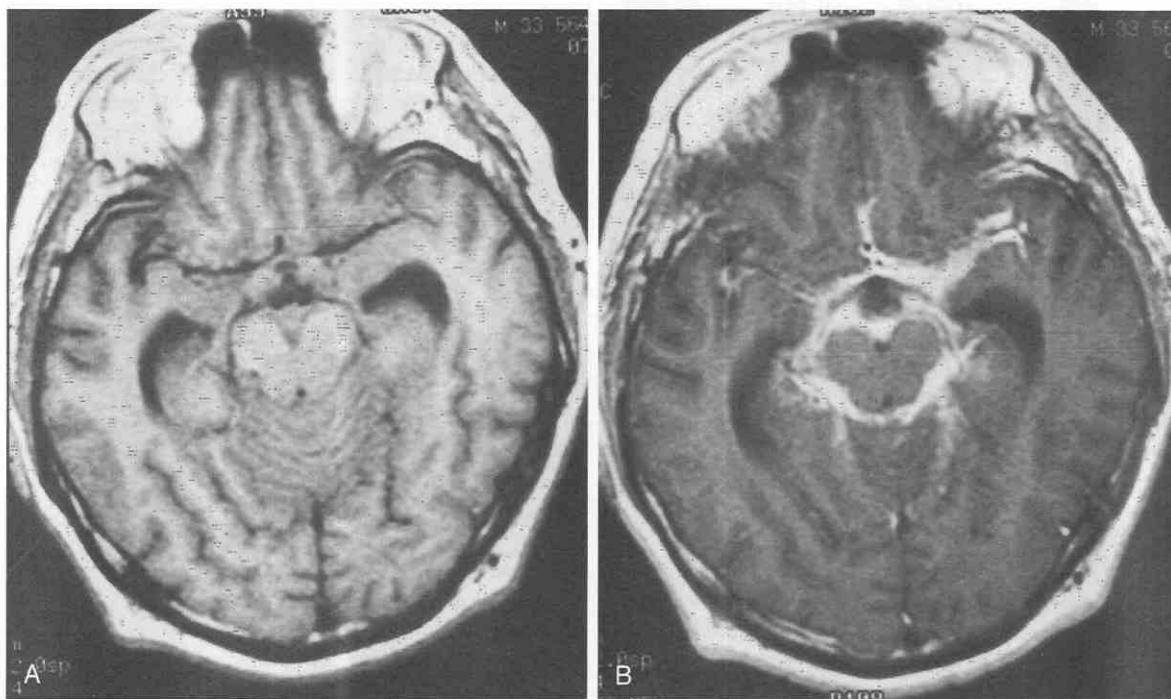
Coccidioidomycosis meningitis. A, T1-weighted image shows isointense granulomatous tissue in the suprasellar cistern. B, Gadolinium-enhanced image demonstrates intense enhancement in the basal cisterns.
